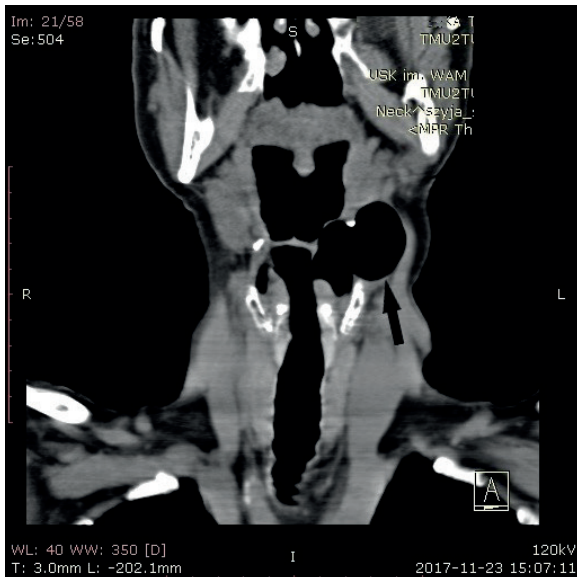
CT frontal view: visible laryngocele
